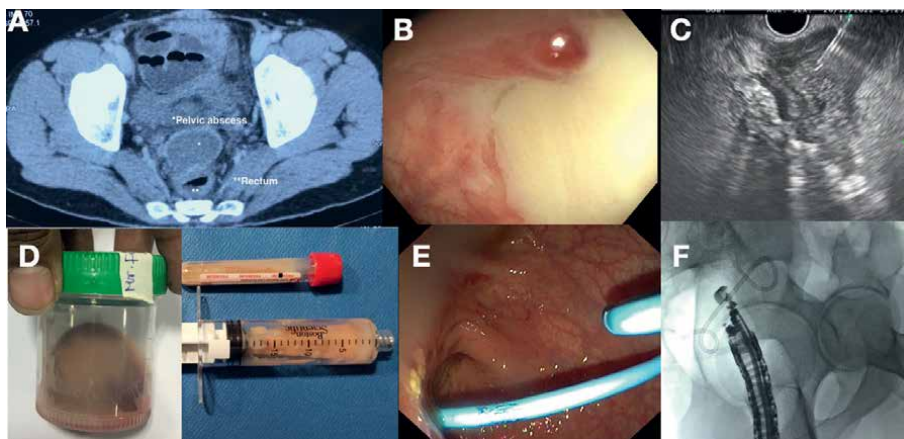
Endoscopic ultrasound (EUS) guided drainage of pelvic abscess. A. Computed tomography shows pelvic abscess anterior to anterior rectal wall, B. Pus draining from fistulous opening on colonoscopy, C. EUS guided puncture and aspiration of pelvic abscess using 19 G fine needle aspiration needle, D. Aspirated pus, E. Pigtail stent placed under EUS guidance after tract dilation with 6 Fr cystotome, F. Fluoroscopy showing echoendoscope and pigtail stent.
